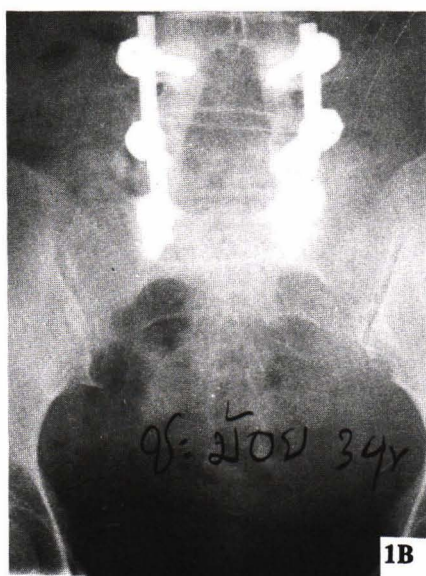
(B-E). The 3rd year follow-up X-ray pictures of 76 years old woman, who was performed decompressive laminectomy and PL fusion with laminospinous process bone graft.
